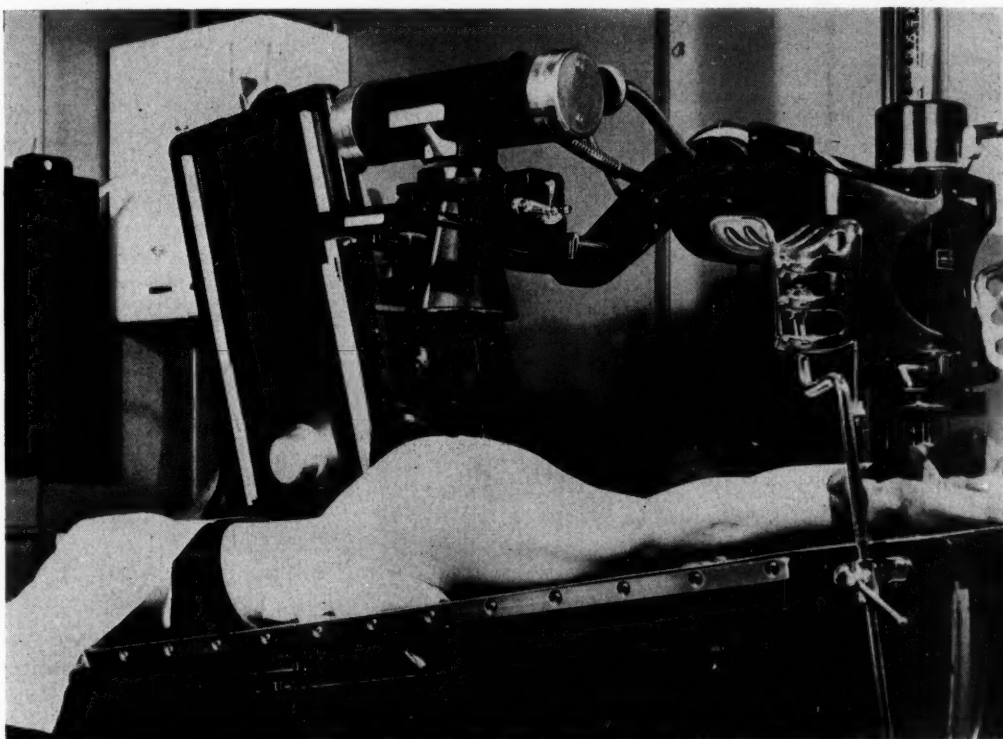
Patient in position on x-ray table. The head is canted down 15 degrees.
